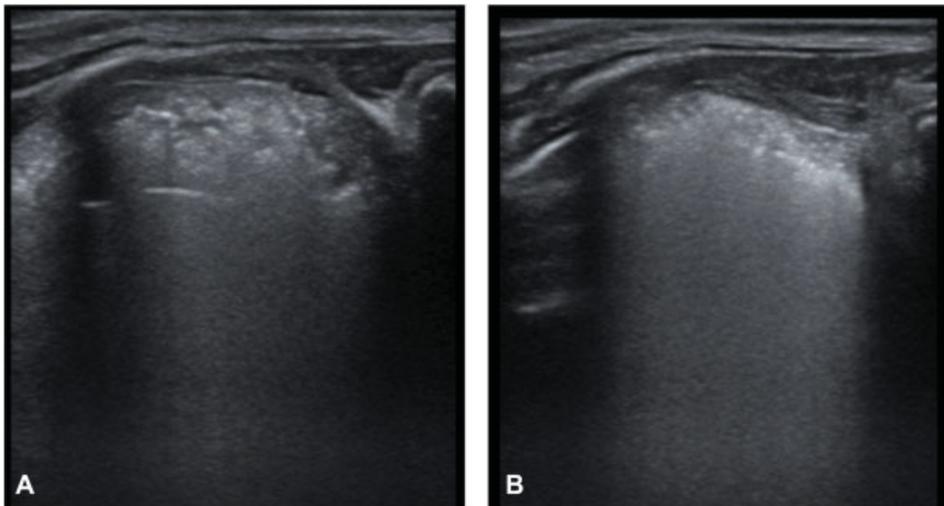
(A, B) LUS-DOL 1: lung consolidation of left posterior lower lobe. DOL, day of life; LUS, lung ultrasound.
